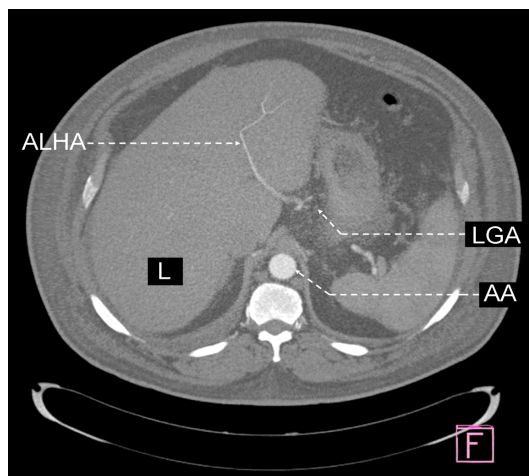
MDCT angiography of the AA. MIP image shows the liver, AA with LGA and ALHA: transversal image. MDCT: Multidetector computed tomography; AA: Abdominal part of aorta; MIP: Maximum intensity projection; LGA: Left gastric artery; ALHA: Accessory left hepatic artery; L: Liver.
